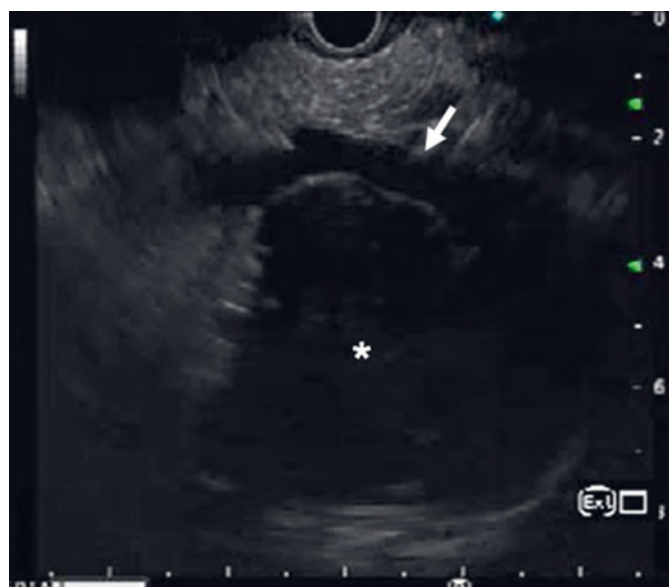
Endoscopic ultrasound shows a hypoechoic mass (asterisk) at the porta hepatis abutting the portal vein (arrow). Image courtesy of: Dr Deepak Gunjan.
